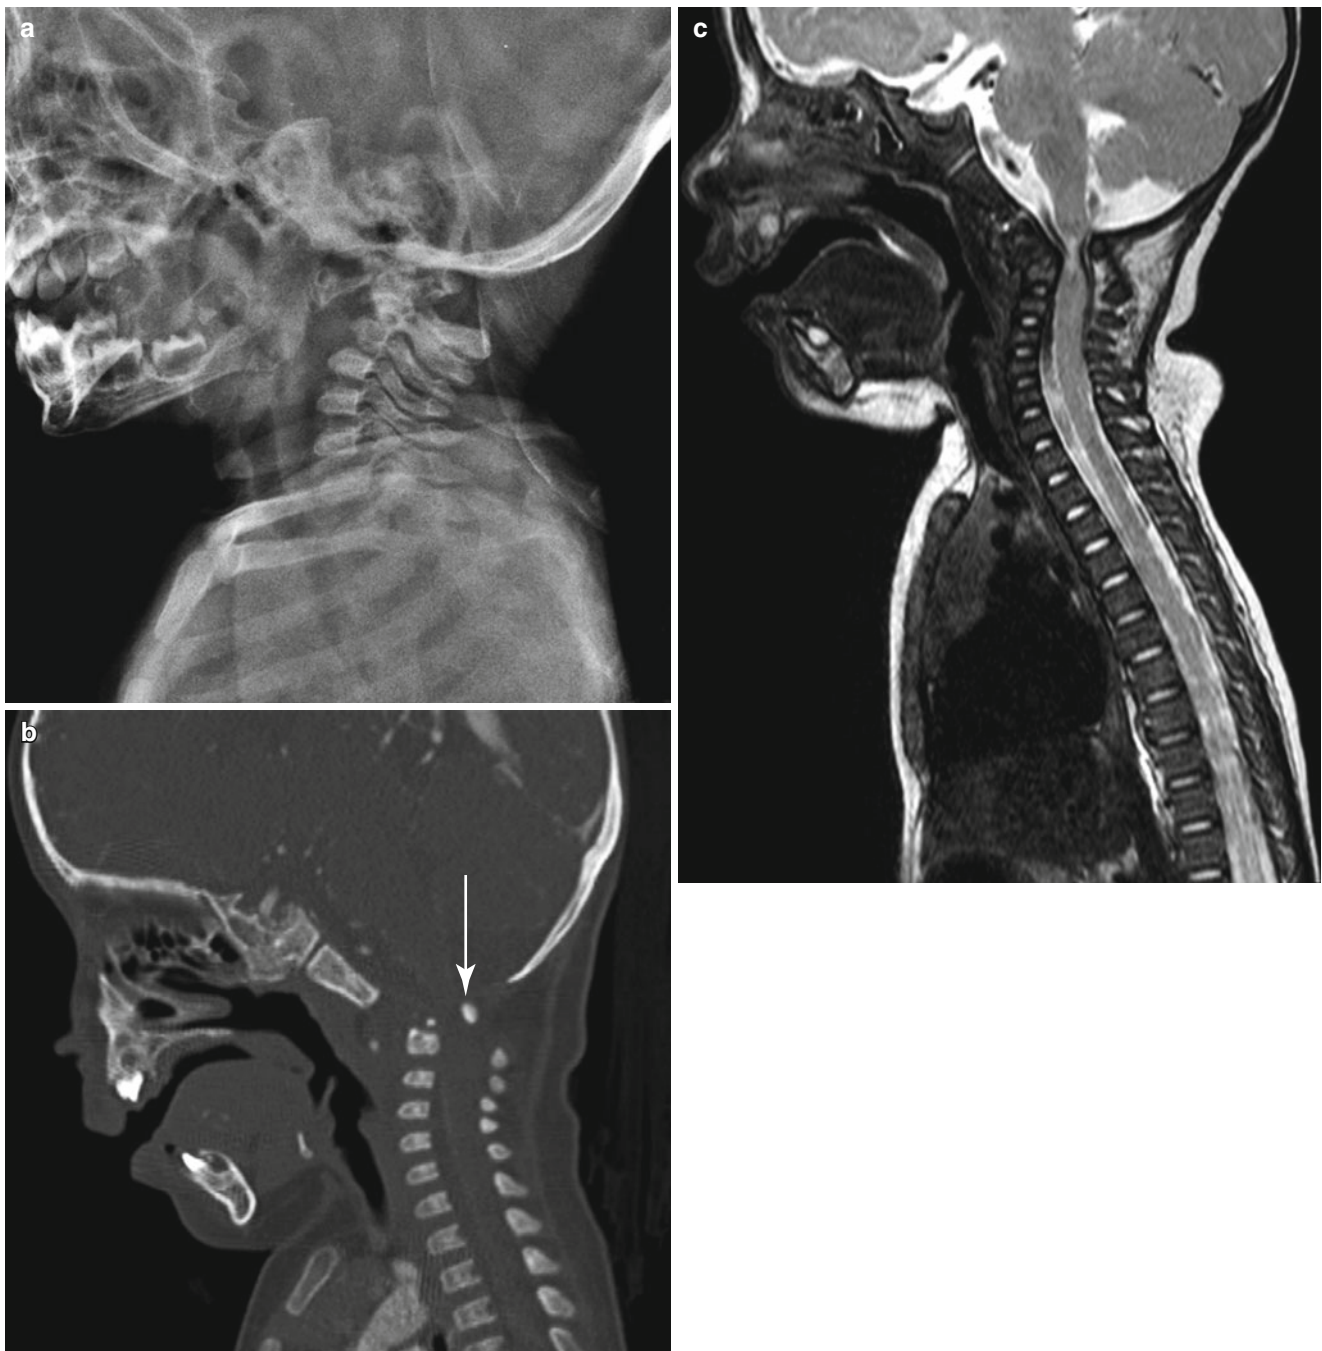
C1–2 dislocation in a 5-month-old boy with quadriparesis. (a) Cervical spine lateral projection shows wide atlantoaxial distance. (b) Cervical spine CT with sagittal reconstruction shows anterior dislocation of C1 on C2 and severe cord compression by the posterior arch
